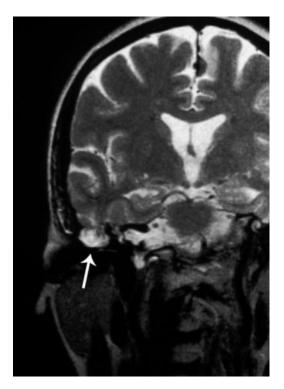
Magnetic resonance imaging (MRI), coronal view. The mass occupying the middle ear is clearly in continuity with the cerebral tissue (arrow).
